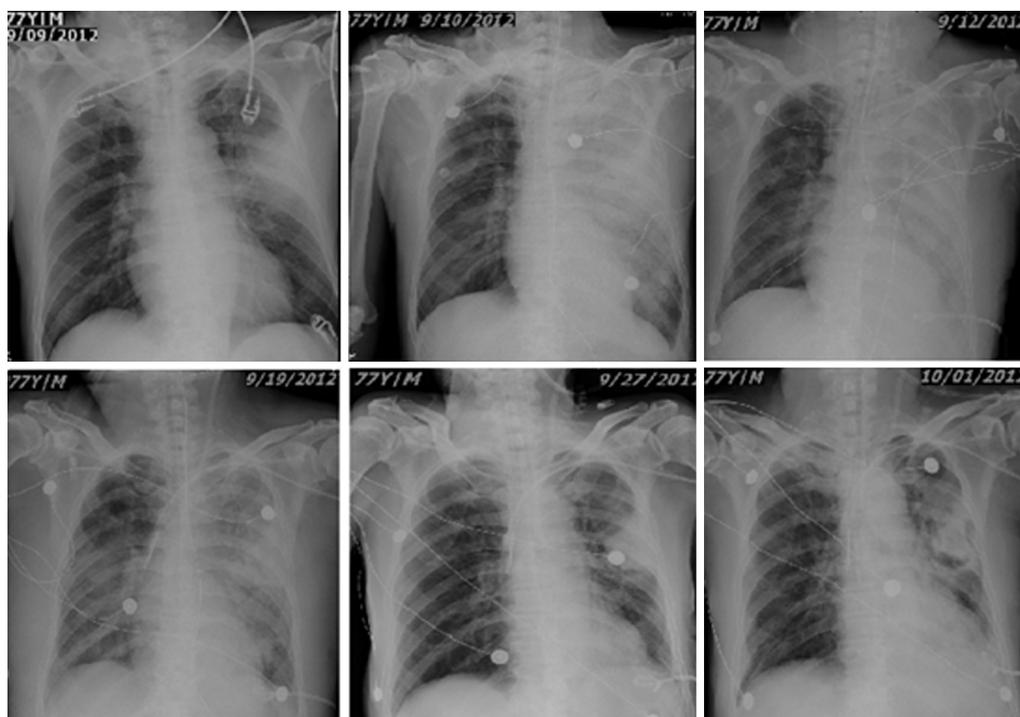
Series of chest X-rays (left to right, then up to down) showing rapid progress of the left lung extensive consolidation and slow resolution after antibiotic therapy in our patient with acute *Aeromonas veronii* pneumonia.
